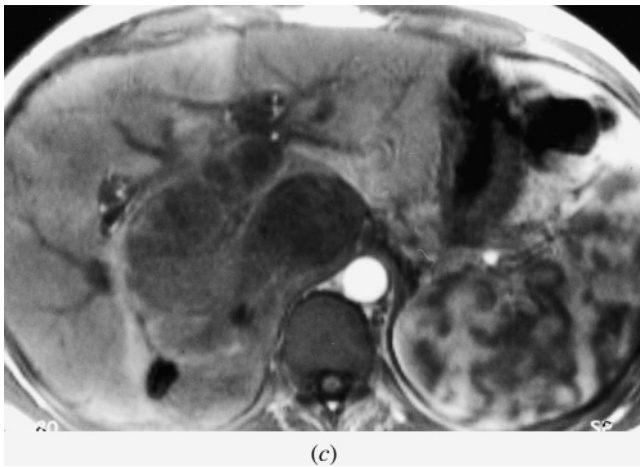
(*Continued*) invasion of the IVC. Coronal T2-weighted SS-ETSE (e) and transverse T1-weighted immediate (f) and 2-min fat-suppressed (g) postgadolinium SGE images in a second patient. There is a large mass in the right upper quadrant that compresses the IVC anteriorly (arrow, g). This mass is heterogeneously increased signal on T2-weighted sequences and demonstrates mild heterogeneous enhancement after gadolinium administration. T1-weighted late-phase fat-suppressed postgadolinium SGE (h) image in a third patient. An irregular heterogeneous mass is evident in the superior aspect of the right renal fossa. This lesion invades the right psoas muscle (arrow, h) and the right hepatic lobe. The tumor also abuts the posterior branch of the right portal vein and the main portal vein.
